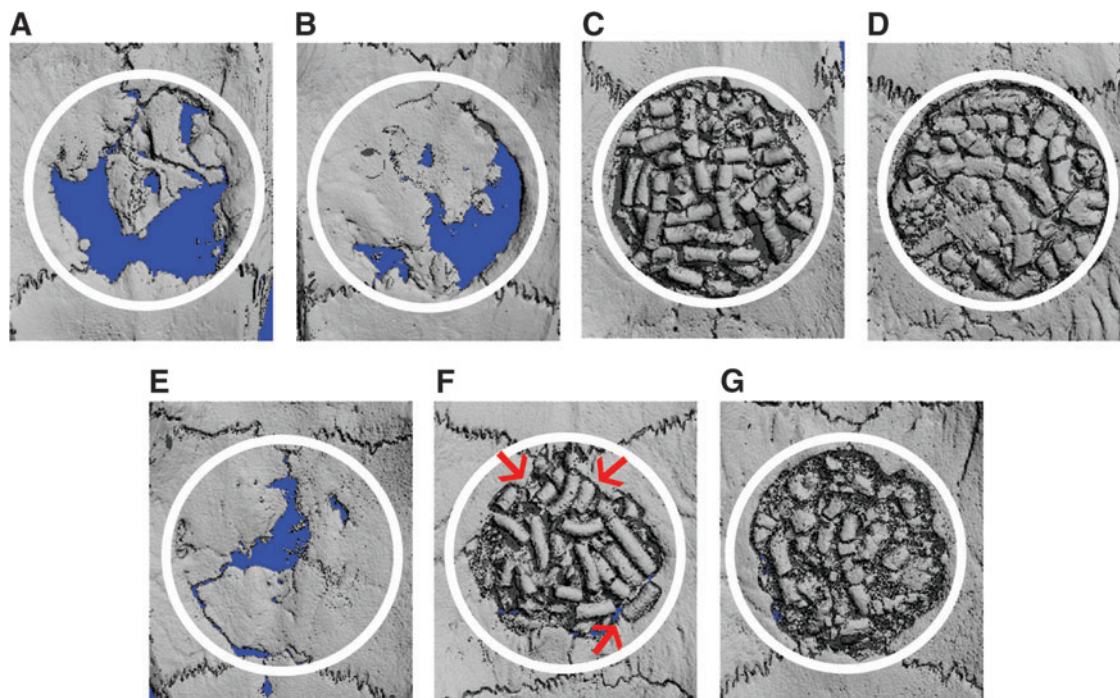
Three-dimensional μ CT view of calvaria defects (ventral aspect) 8 weeks postimplantation. (A) Empty defect–G1; (B) poly(lactic-co-glycolic acid) (PLGA)–G2; (C) HAP-GEL–G4; (D) titanium dioxide (TiO₂)-HAP-GEL–G5; (E) bone autograft–G6; (F) TiO₂-HAP-GEL + OD-MAPC–G7; (G) TiO₂-HAP-GEL + MAPC–G8. White circle represents the limits of the 8-mm-diameter defect area. Red arrows: regions of osteointegration. Color images available online at www.liebertpub.com/tea
